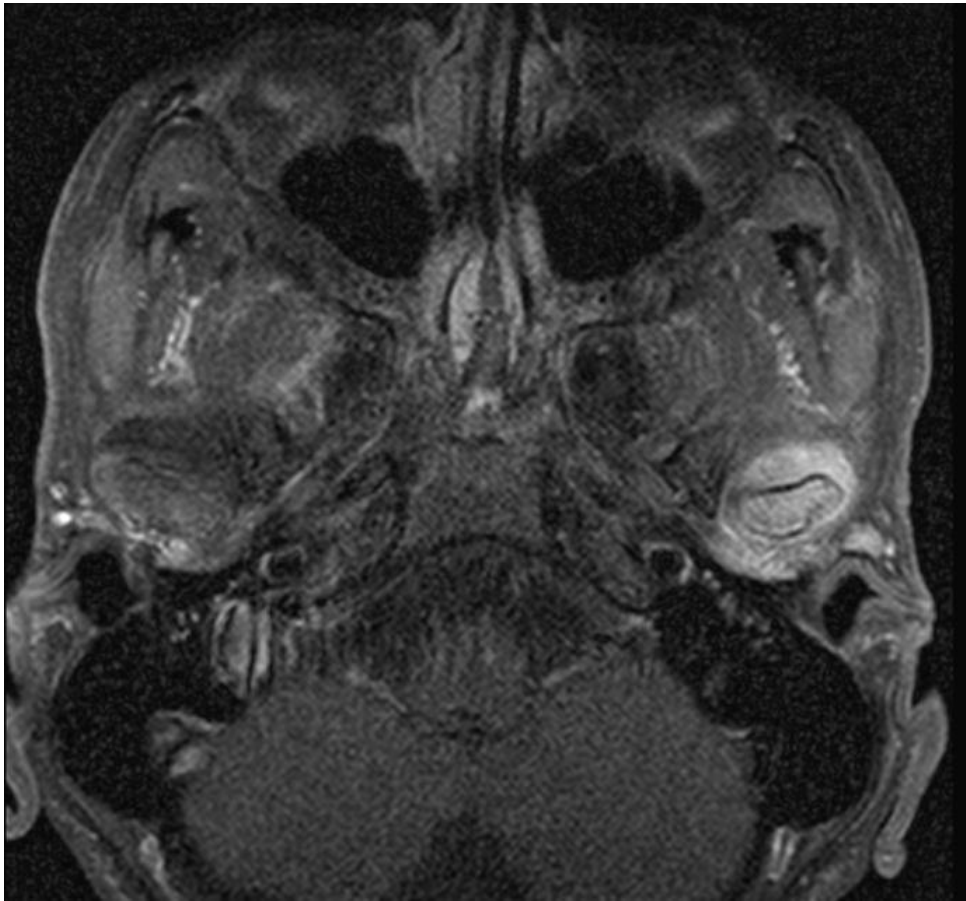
MRI with contrast enhancement, showing synovitis with high intense in the left TMJ of a subject diagnosed with juvenile idiopathic arthritis.
